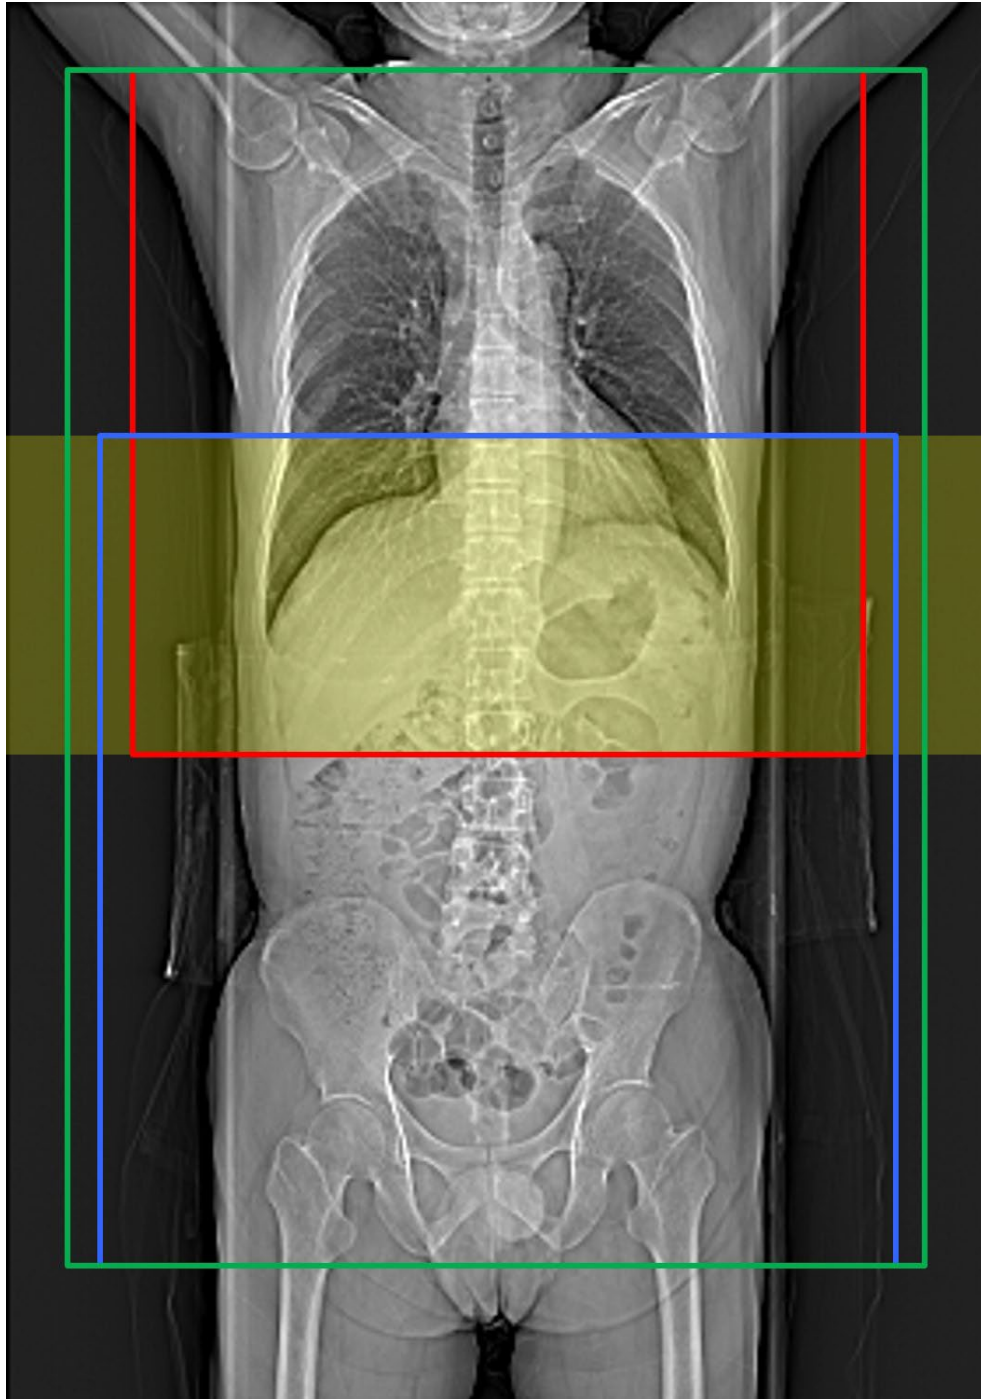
Example of a trunk scout computed tomography image demonstrating the scan ranges of the chest, abdomen–pelvis, and chest–abdomen–pelvis. The red, blue, and green rectangles indicate the scan ranges of the chest, abdomen–pelvis, and chest–abdomen–pelvis, respectively. The range between the lower chest and upper abdomen, indicated in transparent yellow, was scanned, which is common to all scan ranges.
